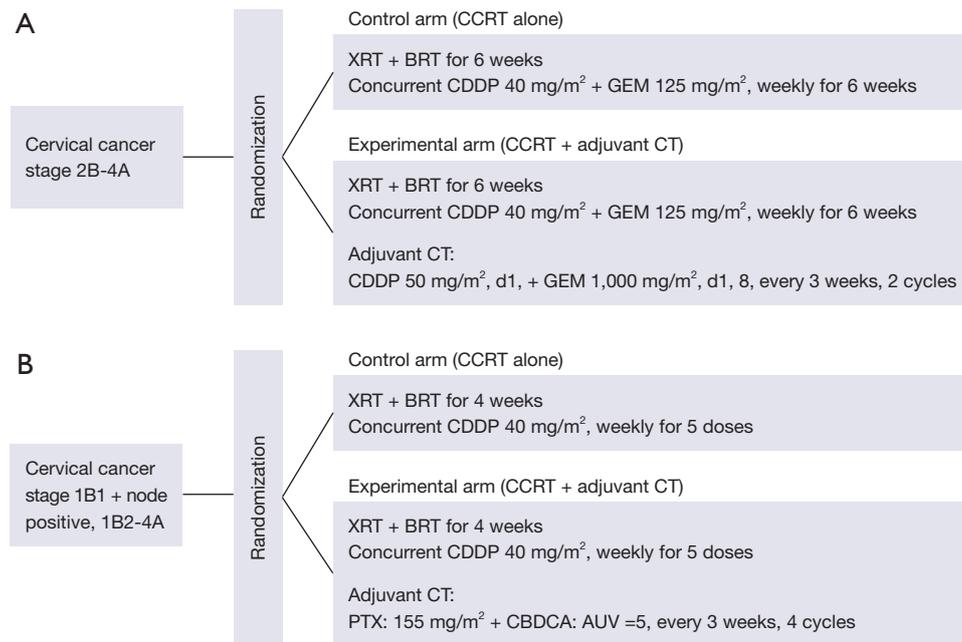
Protocol designs of two randomized controlled studies that CCRT alone with CCRT followed by adjuvant CT. (A) Multinational B9E-MC-JHQS, (B) OUTBACK trial. CCRT, compare concurrent chemoradiotherapy; CT, chemotherapy; XRT, external-beam radiation; BRT, brachytherapy; CDDP, cisplatin; GEM, gemcitabine; PTX, paclitaxel; CBDCA, carboplatin.
